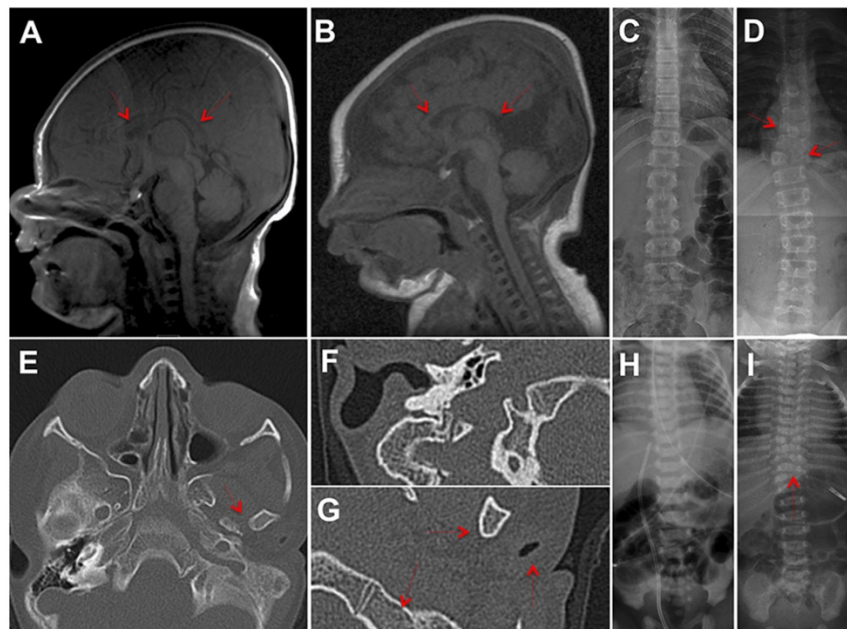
MRI and radiological findings in patients with STAG2 mutations. (A) Healthy three day old female axial T1 weighted MRI view of a normally developed corpus callosum (red arrows). (B) Axial T1 weighted MRI view of patient with STAG2 mutation displaying dysgenesis of the splenium of the corpus callosum (red arrows). (C) Chest X-ray of a healthy 1-day old female demonstrating normal vertebral development. (D) Chest X-ray of a patient with STAG2 mutation demonstrating scoliosis and vertebral abnormalities including hemi-vertebrae and “butterfly” vertebrae (red arrows). (E) Axial view of bilateral auditory canals in a patient with a STAG2 mutation, showing absence of the left auditory canal (red arrow). (F) Higher magnification of the right auditory canal image shows patent canal and normal bone structures. (G) Higher magnification of the left auditory canal demonstrating external auditory canal atresia with a fused ossicular mass, absent stapes, and severely stenotic oval window (red arrows). (H) Chest X-ray of a healthy 8-year-old female demonstrating normal vertebral development. (I) Chest X-ray of a patient with STAG2 mutation demonstrating scoliosis and vertebral abnormalities including hemi-vertebrae (red arrow). [Color figure can be viewed at wileyonlinelibrary.com]
